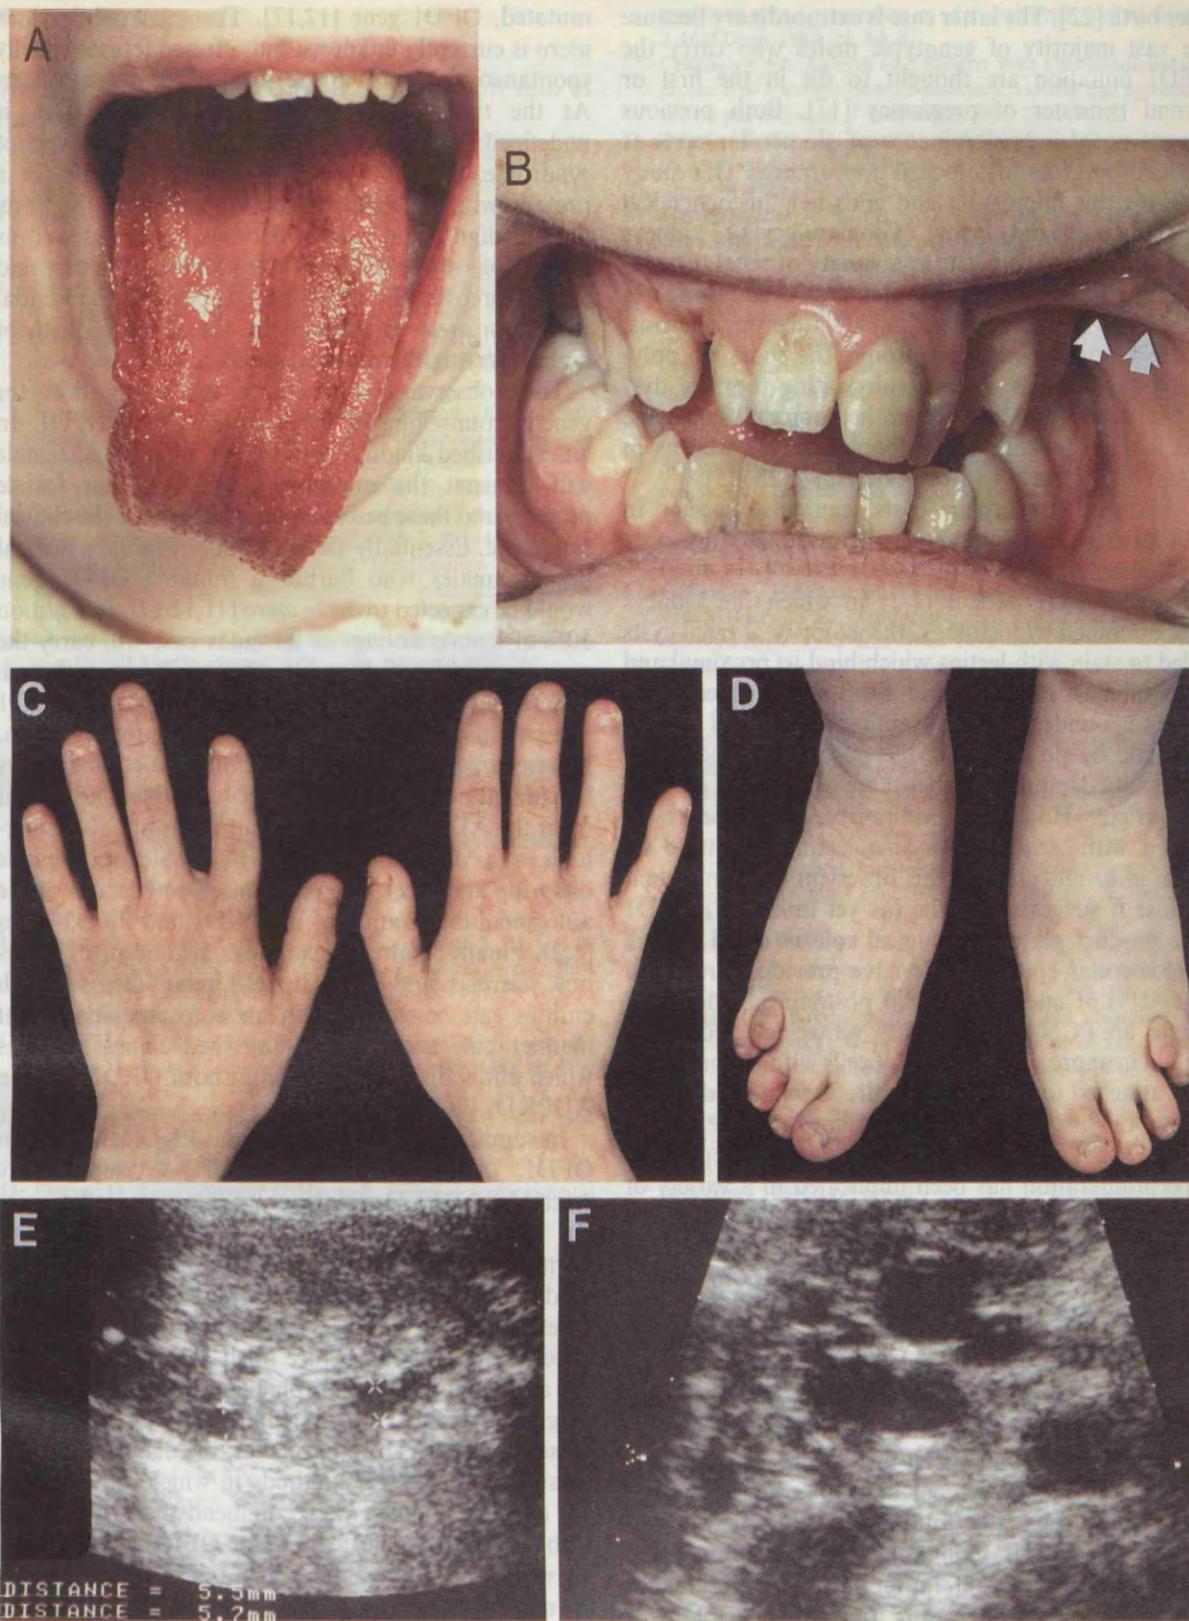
Dysmorphic and radiological features of the OFDI kindred. A. Individual III-1 had marked dysmorphic features: note the irregular clefting of the tongue. B. An oral frenulum (arrow) and abnormal dentition (missing lateral incisors) in III-1. C. Shortened index finger (brachydactyly) in left hand of III-1. D. Bilateral dysmorphic toes (brachydactyly of 4th digits) of III-1. Note the pitting oedema of this teenage patient, who was treated with peritoneal dialysis. E. Ultrasound scan of kidney of III-2 detected cysts of up to 5 mm in diameter. F. Ultrasound scan of III-1 showing a polycystic pancreas.
